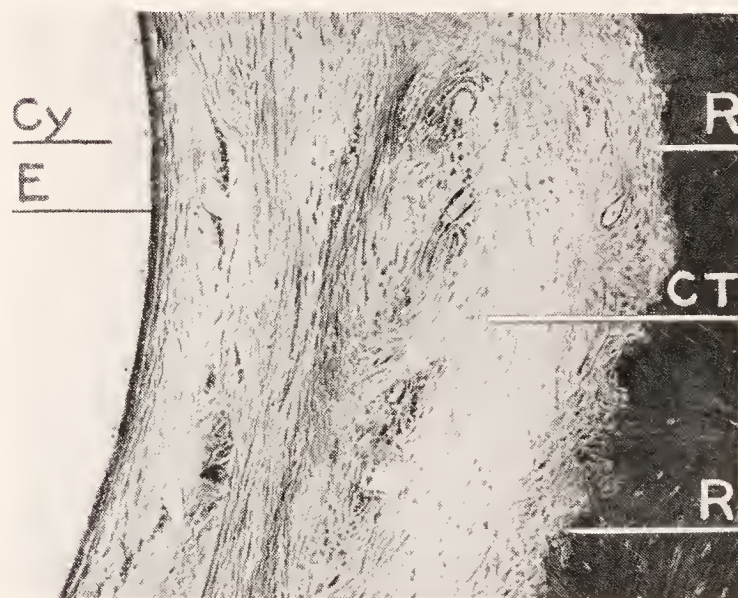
Higher magnification of the cyst wall in Fig. 342. Cy, cyst cavity; E, epithelial lining; CT, connective tissue surrounding the cyst; R, resorption of the bone. (Kronfeld, *Korr. f. Zahnärzte.*)
